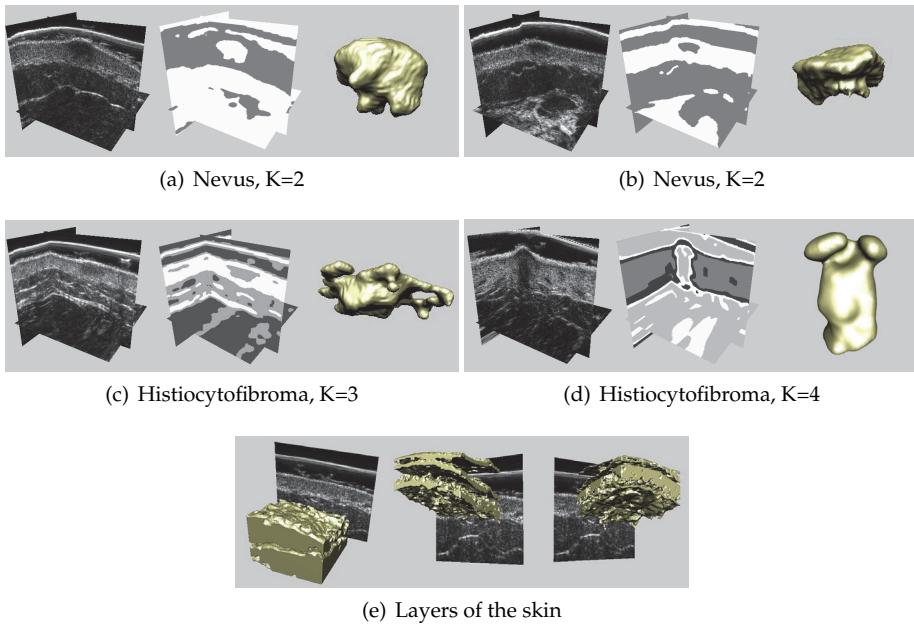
Segmentation of three-dimensional ultrasound images of the skin
